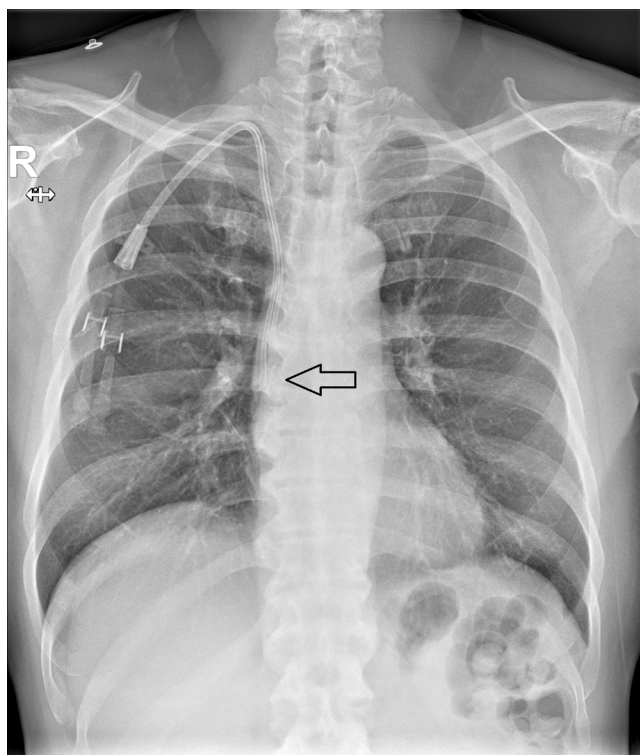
Preoperative chest radiograph with Perm catheter tip in place (black arrow).
